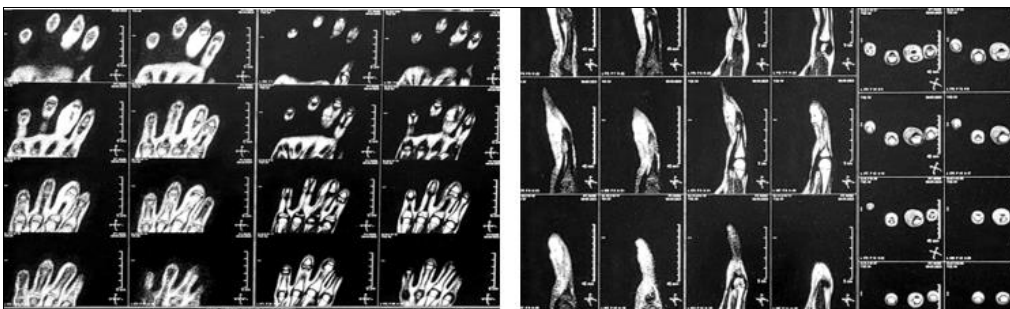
Magnetic resonance imaging (T2 weighted, axial section) showing hyperintense mass lesion involving the adductor compartment of the Right Hand with Fingers
